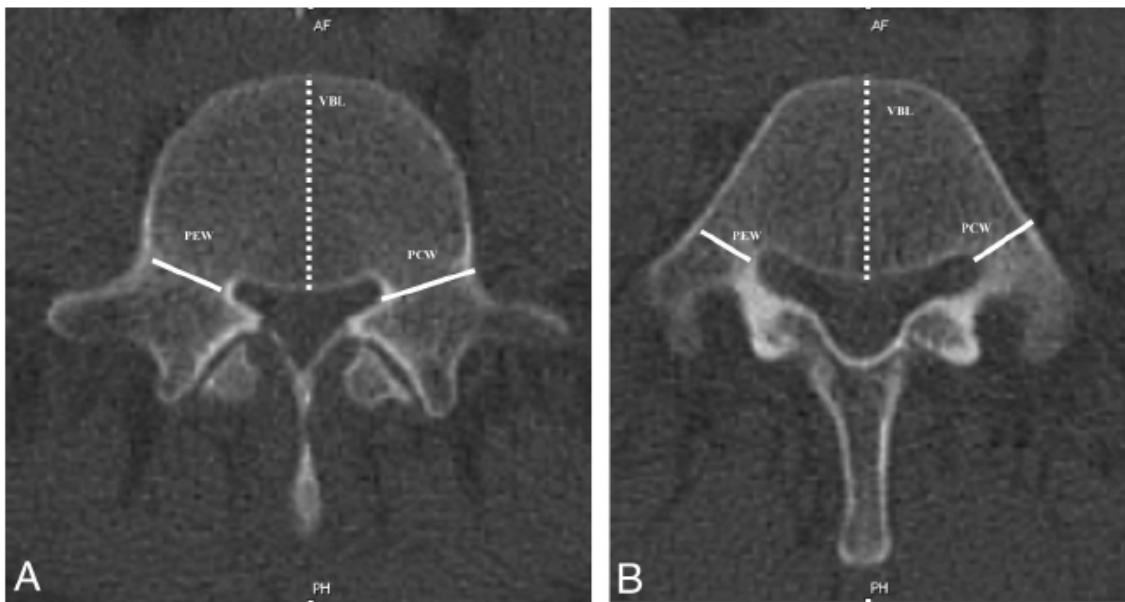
A, Pedicular cortical width (PCW), pedicular endostal width (PEW), and vertebral body length (VBL) in a CT slice in the upper part of the pedicle. B, Pedicular cortical width (PCW), pedicular endostal width (PEW), and vertebral body length (VBL) in a CT slice in the lower part of the pedicle.
